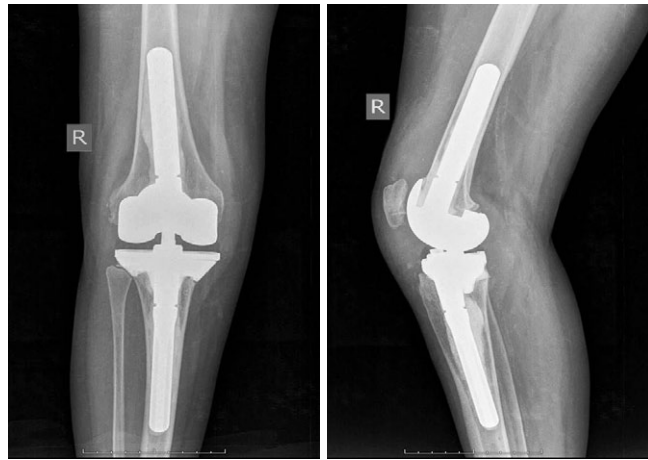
Postoperative X-rays of the right knee in direct and lateral projections
